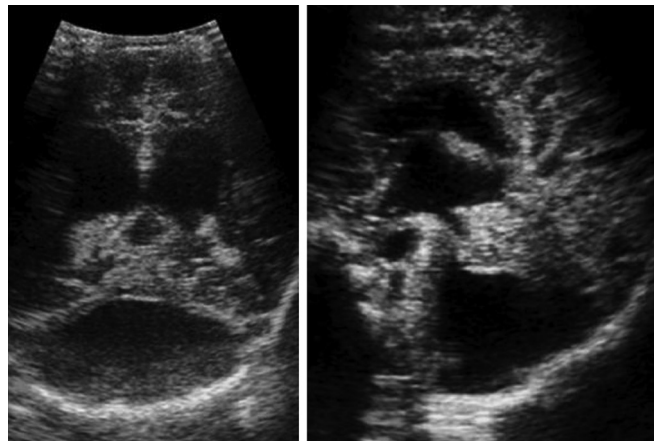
(a) Coronal & 3(b) sagittal ultrasonography images show marked ventricular dilatation in a newborn infant. The lateral ventricles are enlarged, as is the third ventricle.
